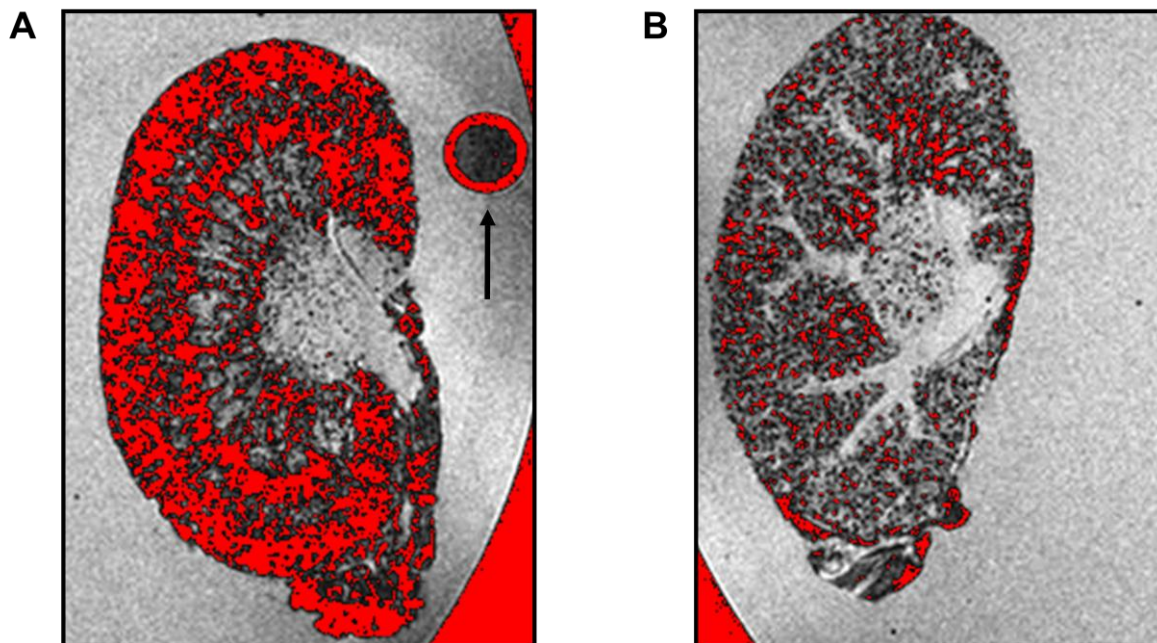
Quantification of MPIO related contrast effects on *ex-vivo* MRI.
